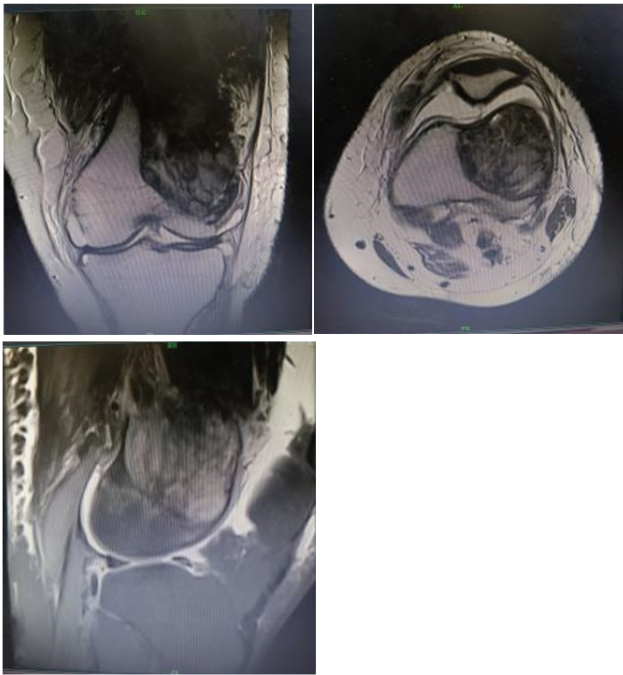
MRI images of left knee
